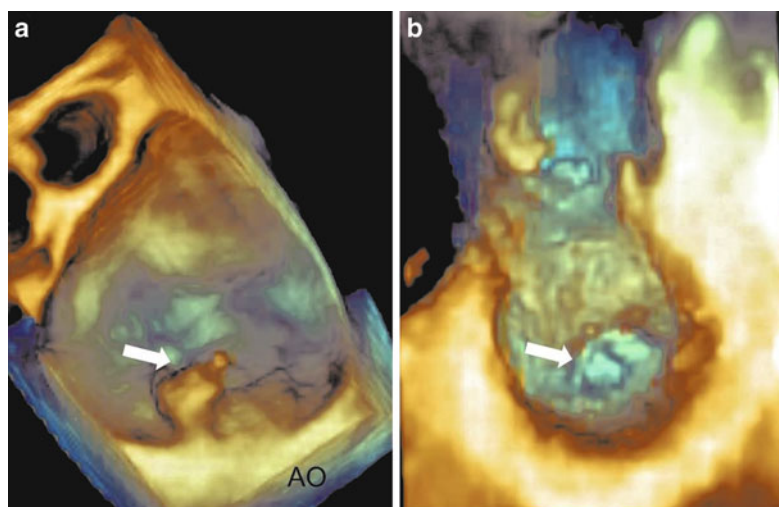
Transesophageal three-dimensional images of the mitral valve from the (a) atrial perspective and (b) ventricular perspective. From the atrial perspective a
